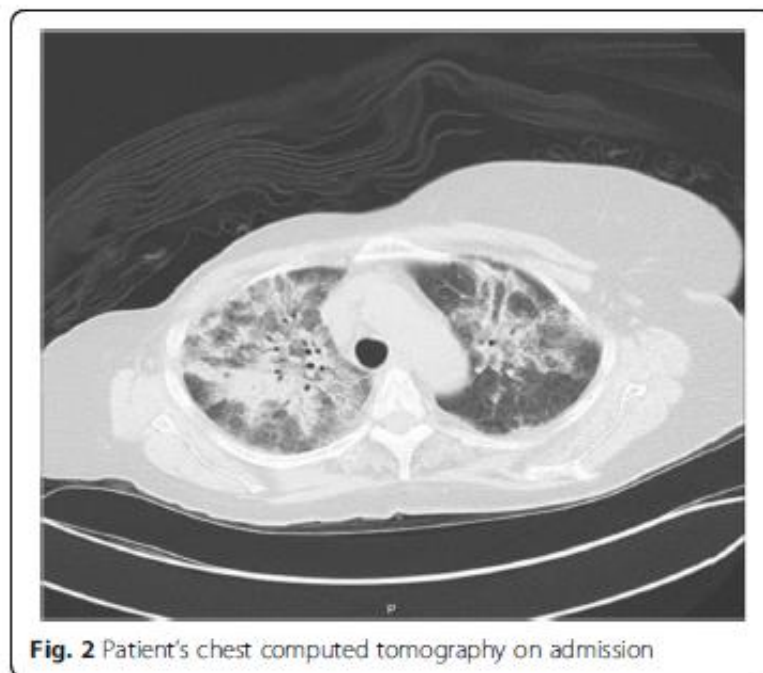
Patient's chest computed tomography on admission
